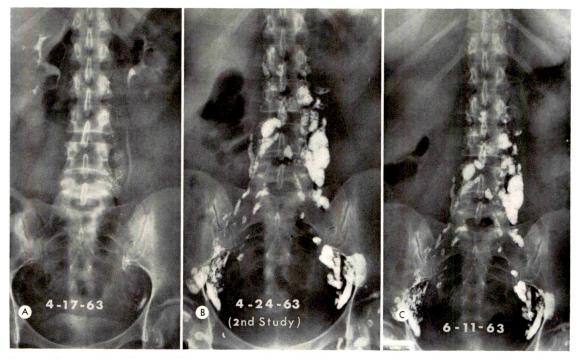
Same case as shown in Figure 10, A and B. (A) Slight deviation of the left ureter and incompletely visualized retroperitoneal lymph nodes still—opacified 2 years after the first lymphangiographic study. (B) A 24 hour roentgenogram following a second injection of oily material discloses further enlargement of retroperitoneal lymph nodes, indicating recurrence of the disease. (C) Two months following radiation treatment, note the reduction in the size of the retroperitoneal lymph nodes.
